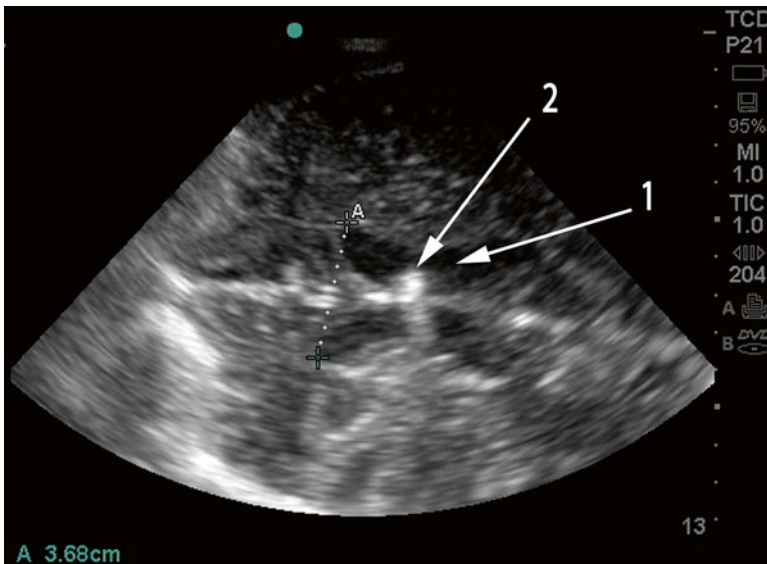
Measurement of lateral ventricular size through craniectomy defect. Measurement of frontal horns for quantification of lateral ventricular size. Distance measured (3.68 cm) is almost identical to distance measured on CT (3.69 cm) in Fig. 15.24. 1 Right lateral ventricle, 2 external ventricular drain
